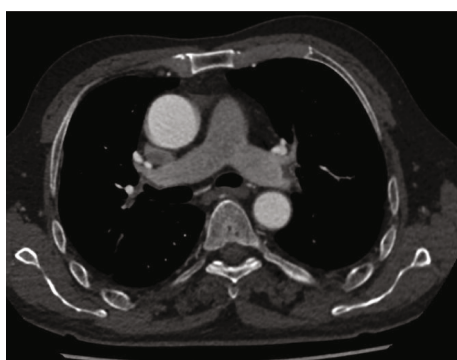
Computed tomography angiography (CTA) showed pulmonary embolism disappearance in the second patient.
